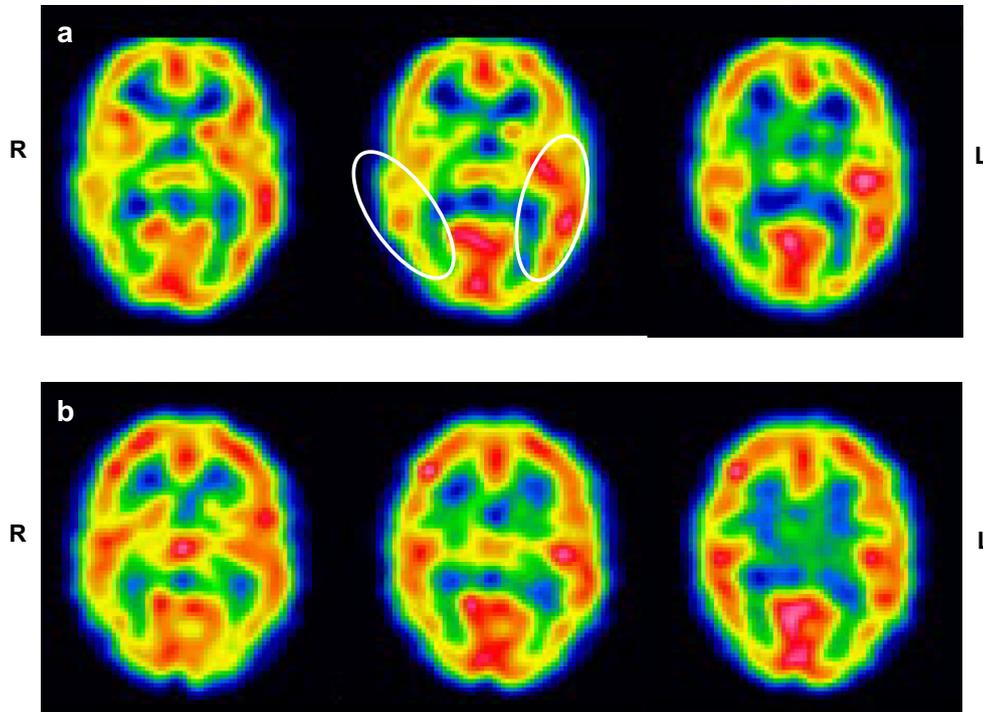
Brain  $^{99m}\text{Tc}$ -ethylcysteinate dimer (ECD)-single-photon emission computed tomography (SPECT) images, (a) ECD-SPECT on the second day after onset showing hyperperfusion in the left temporal to occipital cerebral regions. (b) ECD-SPECT on the tenth day after onset showing no clear difference in cerebral blood flow between left and right hemispheres.
